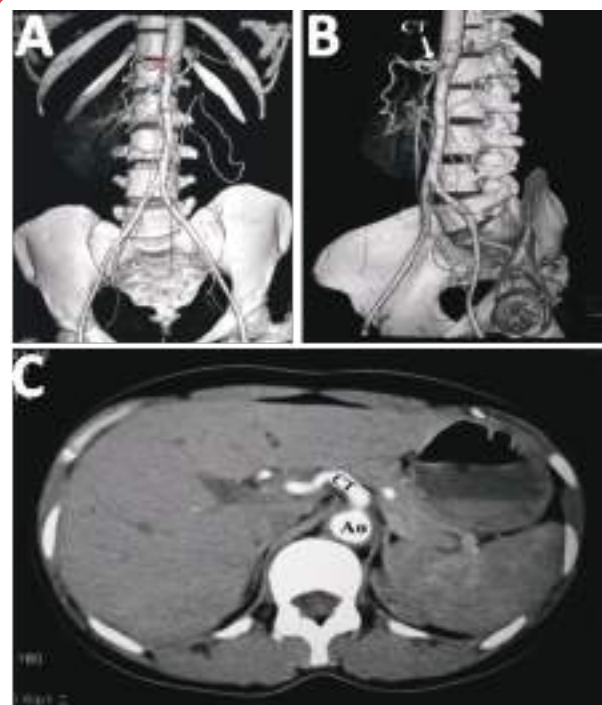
Representative images of reconstructed volumetric 3D rendered CT angiogram in A) AP projection B) sagittal projection showing the origin of the coeliac trunk and its branches. C) Axial section of CT angiogram showing the origin of coeliac trunk from the aorta
